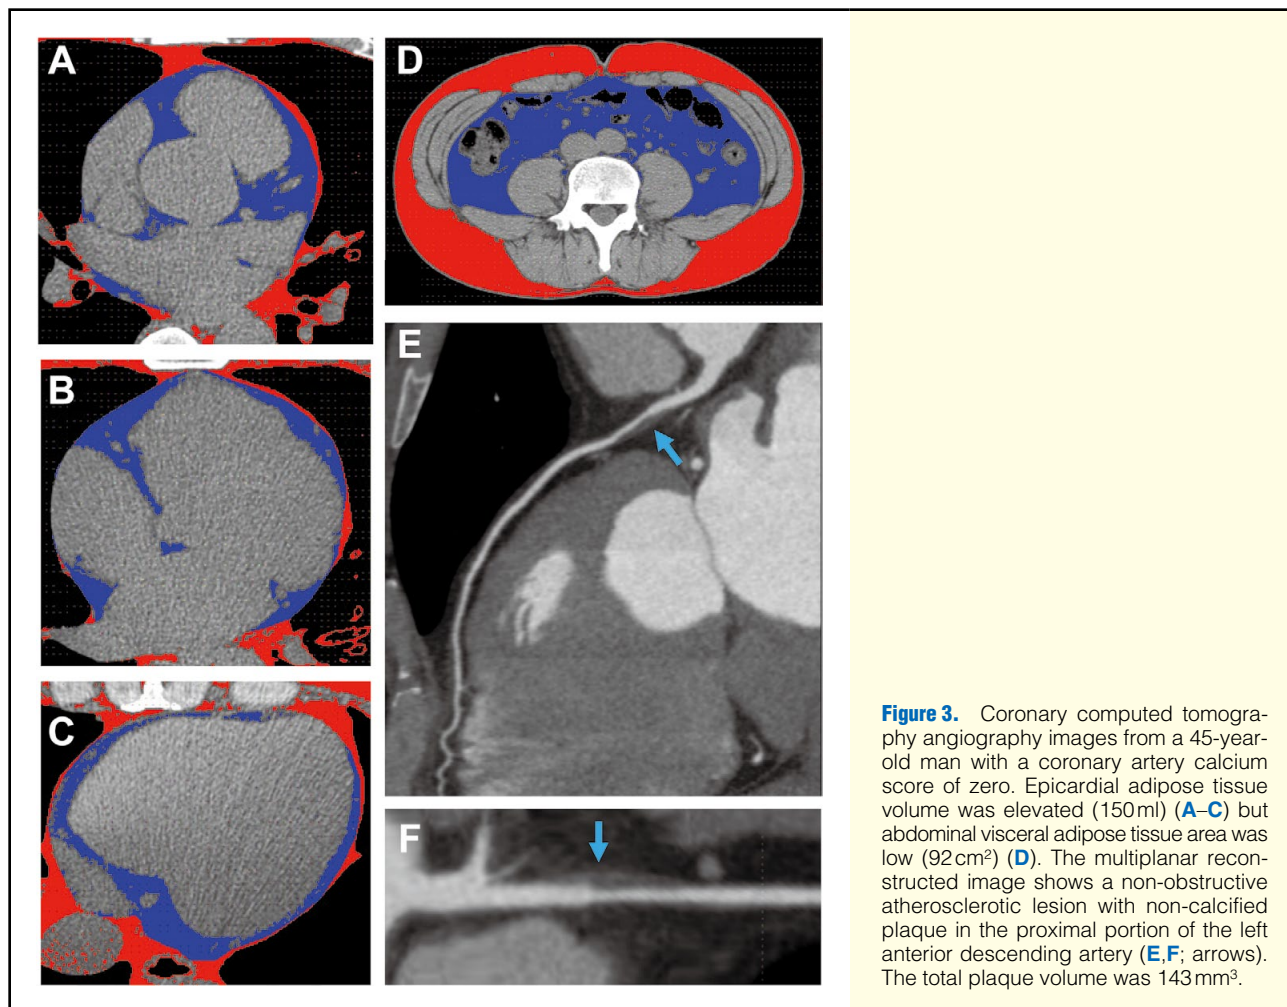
Coronary computed tomography angiography images from a 45-year-old man with a coronary artery calcium score of zero. Epicardial adipose tissue volume was elevated (150 ml) (A–C) but abdominal visceral adipose tissue area was low (92 cm²) (D). The multiplanar reconstructed image shows a non-obstructive atherosclerotic lesion with non-calcified plaque in the proximal portion of the left anterior descending artery (E,F; arrows). The total plaque volume was 143 mm³.
